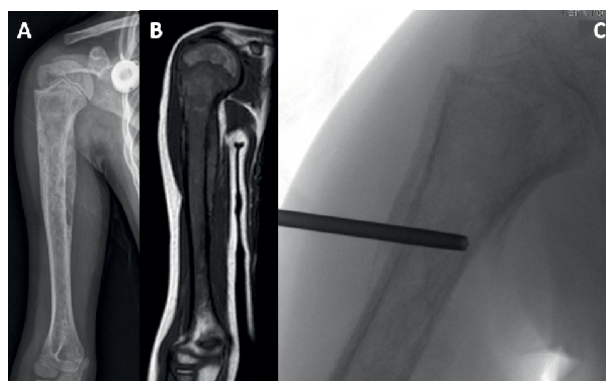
Correct sequence for performing a biopsy procedure. (A) x-ray of the affected limb, (B) local staging (biopsy should be performed after complete systemic staging), and (C) core needle biopsy using fluoroscopy.
